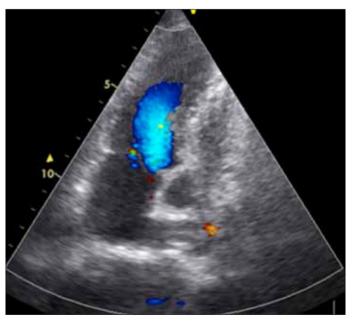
Transthoracic echocardiographic four- chamber view of a normal ventricular function and mild mitral regurgitation
